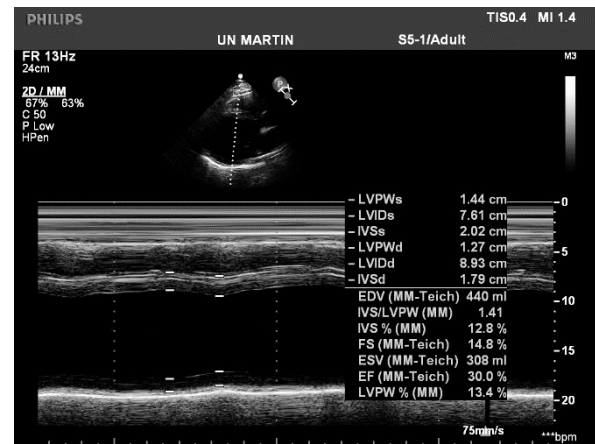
Echocardiogram after 1 year under treatment with somatostatin analogues. LVPWs — posterior wall thickness end systole; LVIDs — left ventricular internal diameter end systole; IVSs — interventricular septal wall thickness end systole; LVPWd — posterior wall thickness end diastole; LVIDd — left ventricular internal diameter end diastole; IVSd — interventricular septal wall thickness end diastole; EDV — LV end-diastolic volume; ESV — end-systolic volume; FS — fractional shortening; EF — ejection fraction
